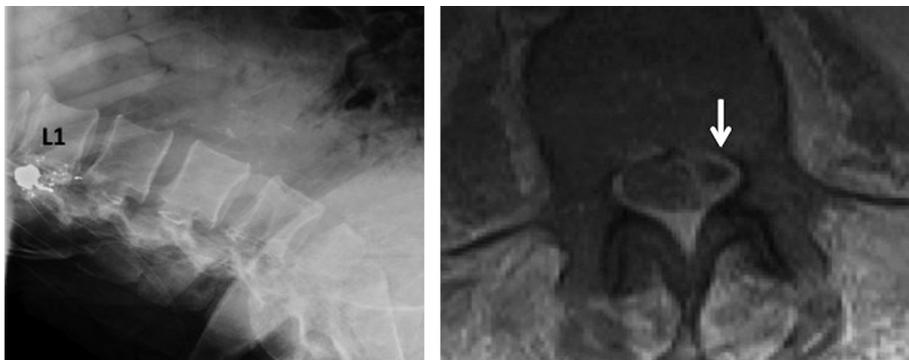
Epidural abscess in a patient with back pain and history of gunshot trauma to the spine. The plain film (left) demonstrates the bullet fragment overlying the first lumbar vertebral body. Other than minimal hypertrophic changes, no abnormalities are identified. However the accompanying magnetic resonance imaging (right) demonstrates a large, compressive epidural abscess (arrow) extending from L4 to S2.
